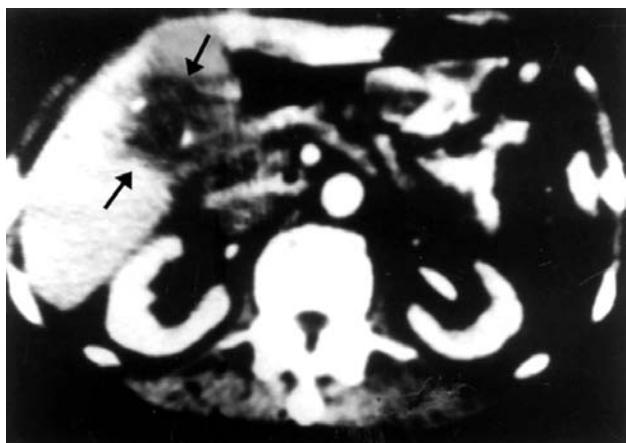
Carcinoma of the gallbladder. CT scan shows a gallbladder carcinoma (→) that obliterates the normal landmarks of the gallbladder
